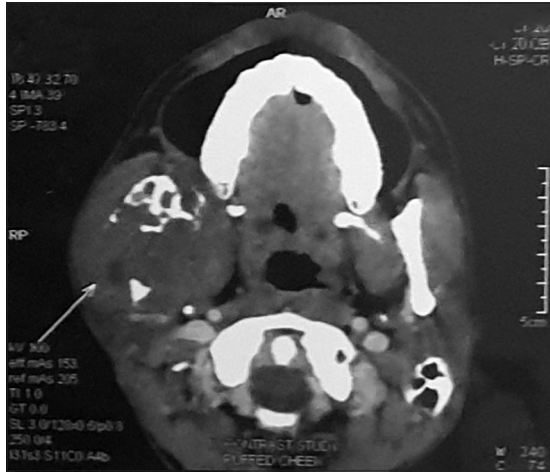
Computed tomography scan shows a destructive lesion in the right hemimandible involving the body, ramus, and condylar process along with heterogeneously enhancing soft-tissue component
